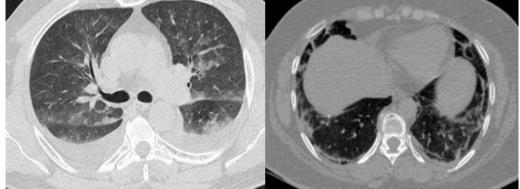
Axial HRCT shows sub pleural band with consolidation involving bilateral lower lobes.
